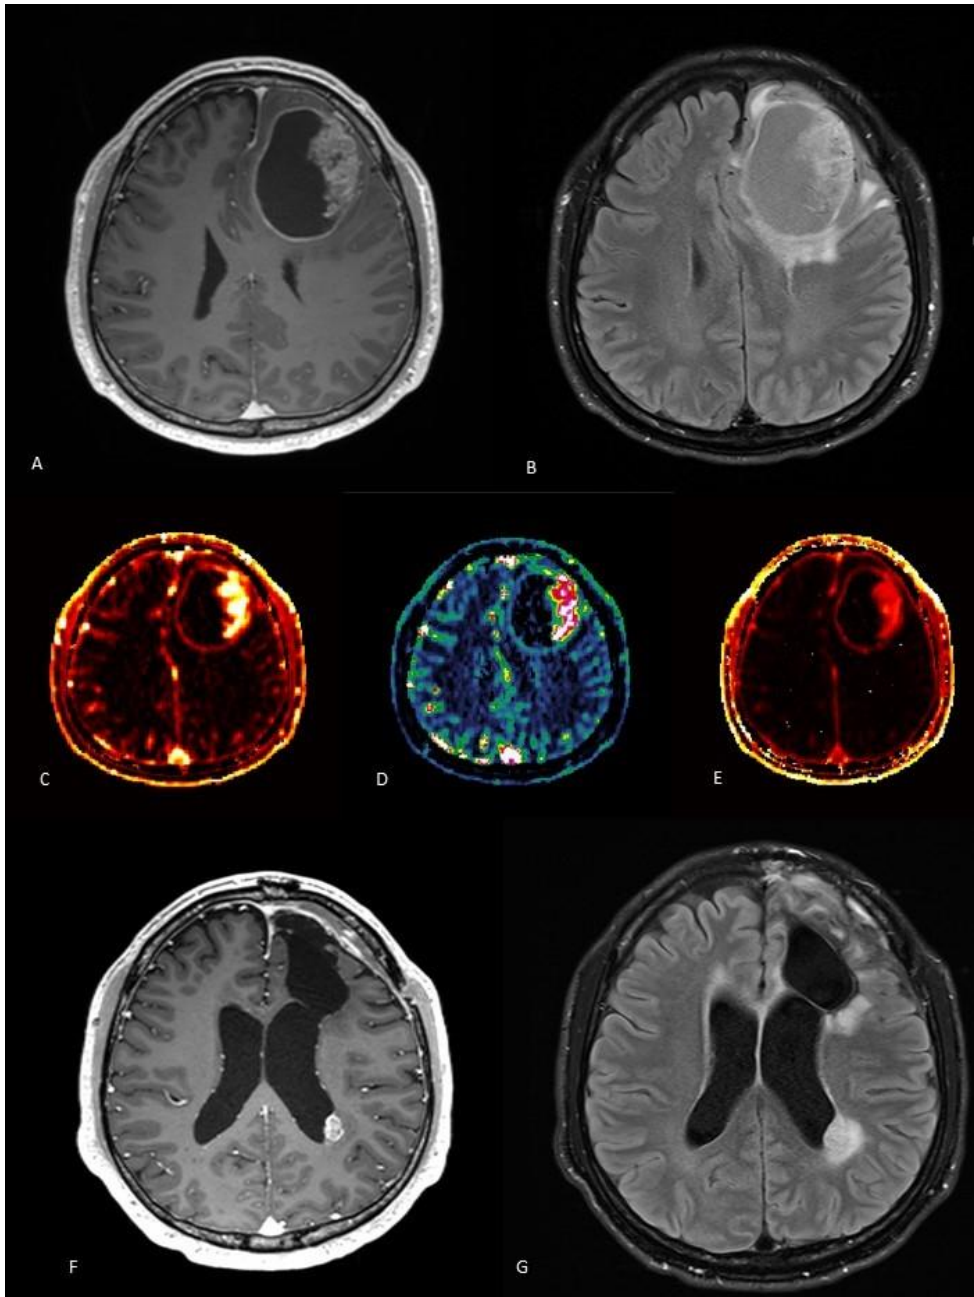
High-risk patient (radiomics risk score: 0.703891). A 43-year-old patient with glioblastoma. A preoperative axial MRI demonstrates a contrast-enhanced lesion with perilesional T2 high signal intensity at the left frontal lobe: (A) Contrast-enhanced T1
